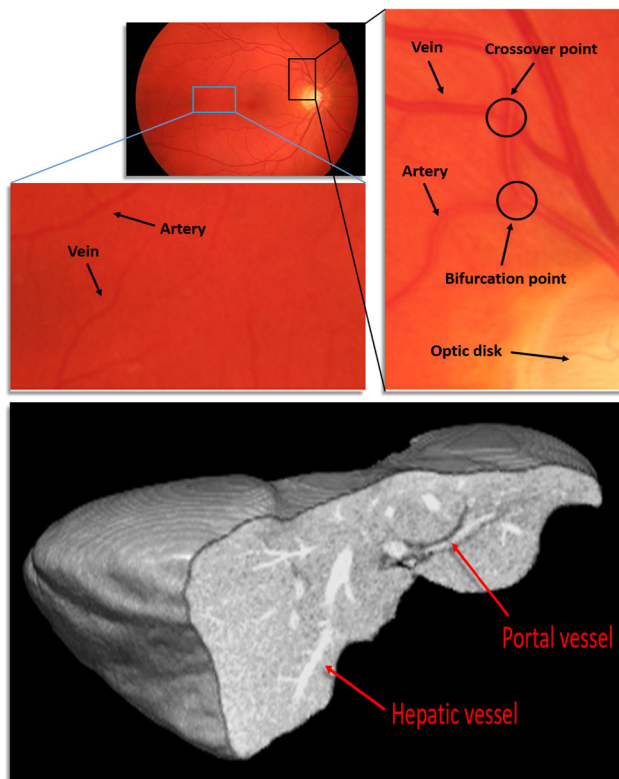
An example of 3-channel color retinal fundus image and of 1-channel grayscale anatomical CT volume of a liver. In the retinal image, the regions near and far from the optic disk regions are zoomed in for better visualization. In the liver image, the regions of portal vessels and hepatic vessels are marked
